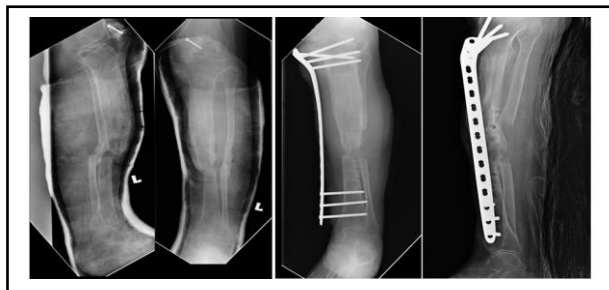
X-ray show non-union of docking site; 1b: X-ray Post supra-cutaneous LCP
